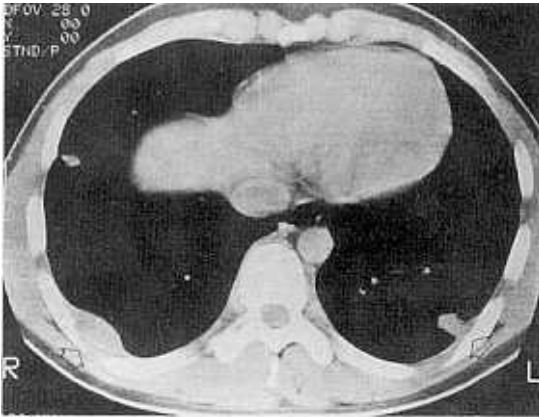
Follow-up chest CT one year later shows newly developed lesions at both sides of lower posterior chest wall.
